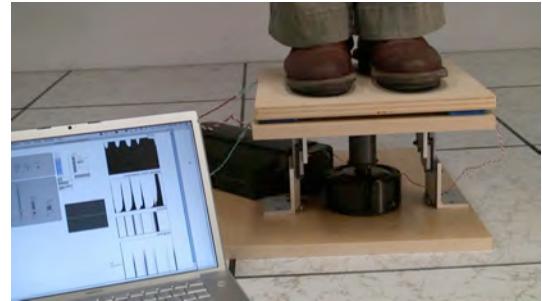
The interactive floor tile with user walking on it, next to the software component running on a laptop computer. The display of the latter shows the force, event density, and a sonogram of the resulting audio/haptic signal.
